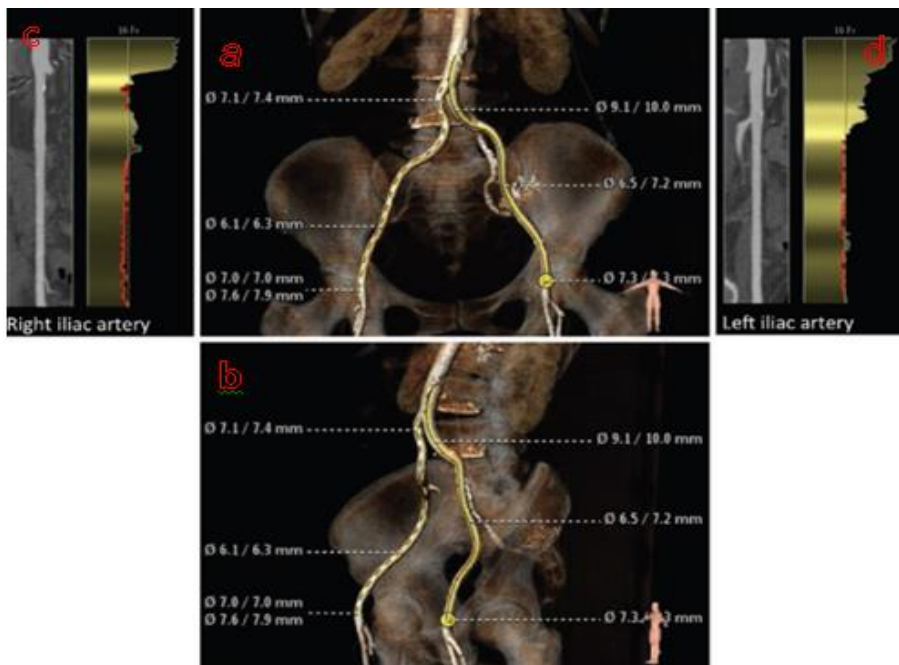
Transcatheter aortic valve implantation: iliac and femoral artery evaluation (TAVR). Images from a contrast abdominal and pelvic CT scan may be used to measure the diameters of the common iliac and femoral arteries at various levels (a-d), which will indicate whether or not a transfemoral approach is possible for inserting the delivery system sheath. It is possible to assess the degree of calcification and tortuosity of a conduit by the use of 3-D reconstruction (a and b).
